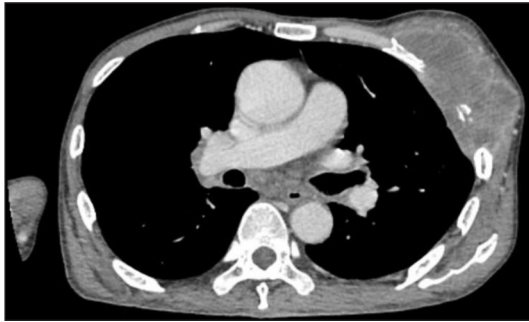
Contrast enhanced CT of the thorax showing a lobulated, heterogeneously enhancing mass occupying the whole left breast measuring 11.1x4.7x9.2 cm with ribs erosion and intrathoracic extension.
